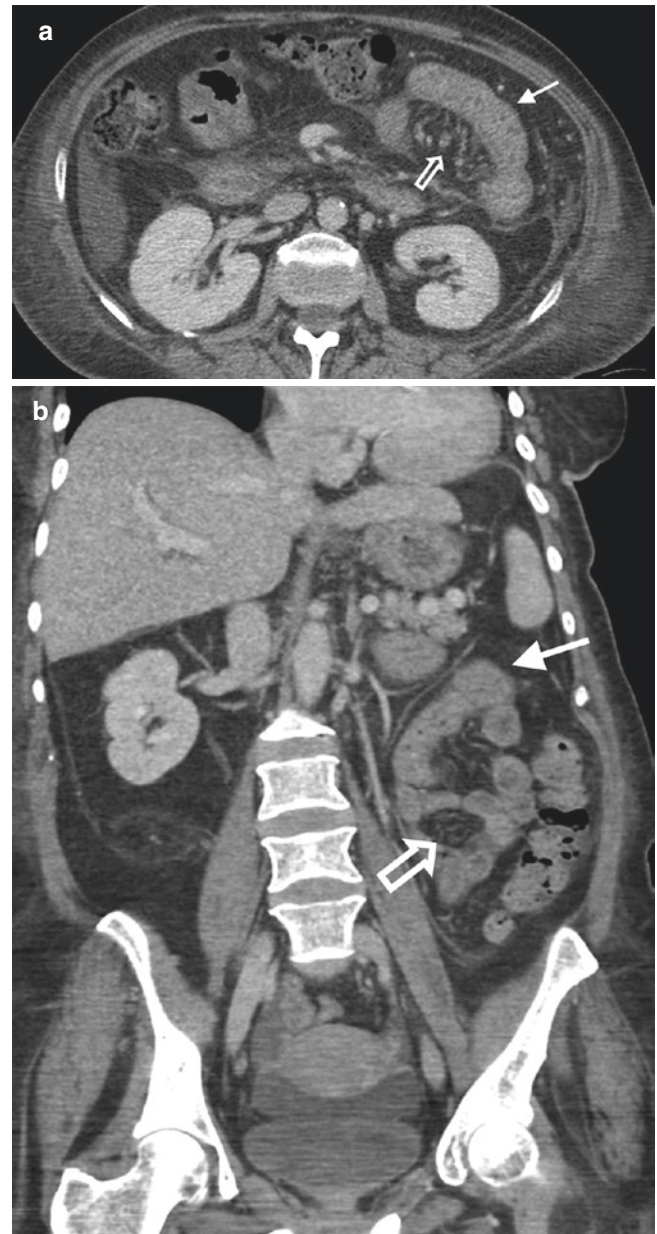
Graft versus host disease. Axial (a) and coronal (b) enhanced CT images of a patient with GVHD, displaying thickened, edematous bowel wall (solid arrow) or normal caliber small bowel loops with engorged mesenteric vessels (hollow arrow)
